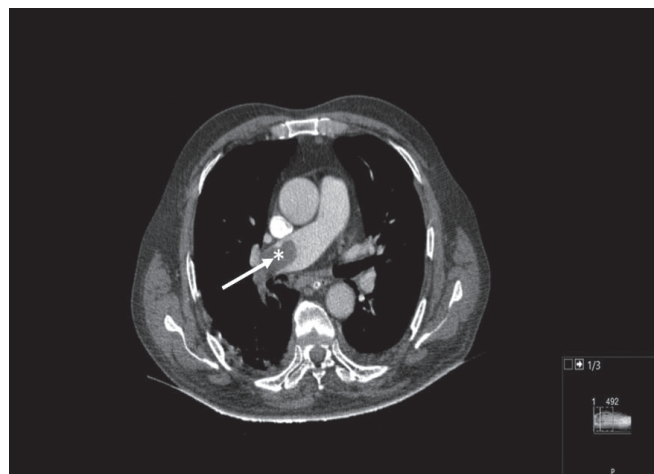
Contrast-enhanced thorax computed tomography scanning the pulmonary artery phase. Filling defect compatible with thromboembolism in the right main pulmonary artery (asterisk and arrow).
